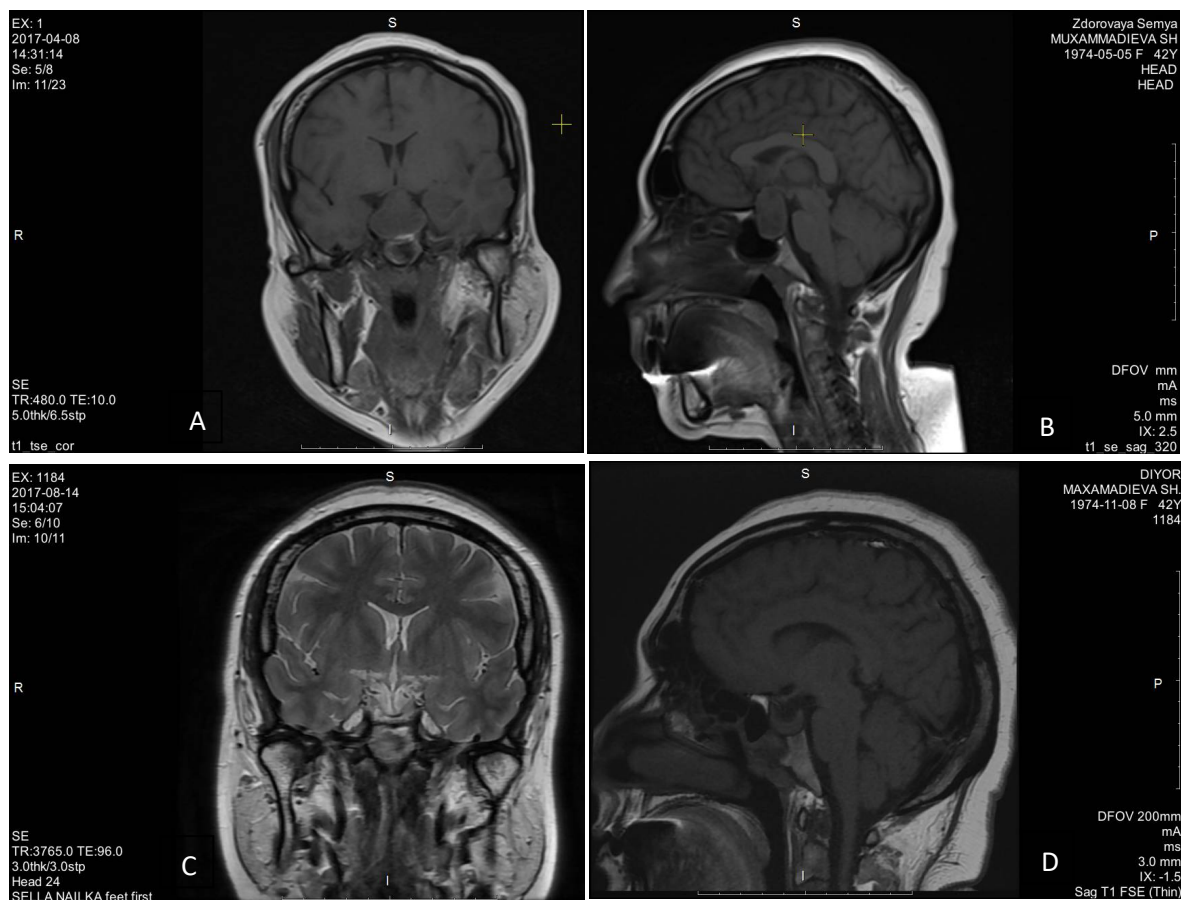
2. MRI of a patient with pituitary adenoma with supra-infra-parasellar growth. A, B before surgery; C, D after surgery
